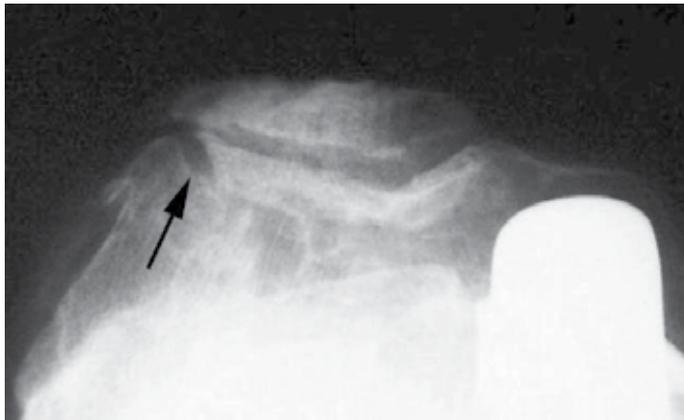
Patellar Infection. A 70-year-old man, nine years after partial knee replacement. Axial radiograph (Merchant view) of the knee prosthesis shows osteolysis on the lateral facet of the femur (arrow) with a non-cemented hemiarthroplasty of the knee, corresponding to a focus of infection, with sclerosis in the patella, suspected of infective infiltration. These findings were confirmed during surgery, and excisional debridement of the infection and total patellectomy were performed. Cultures were positive for *Pseudomonas aeruginosa*.
